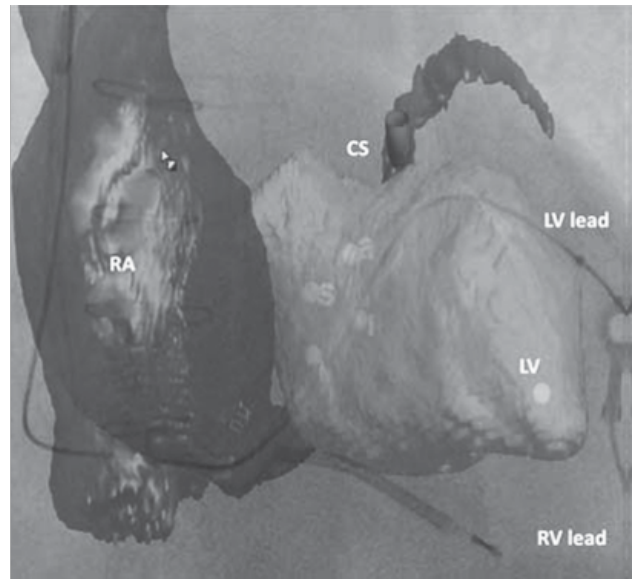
United image (computed tomography + fluoroscopy).
